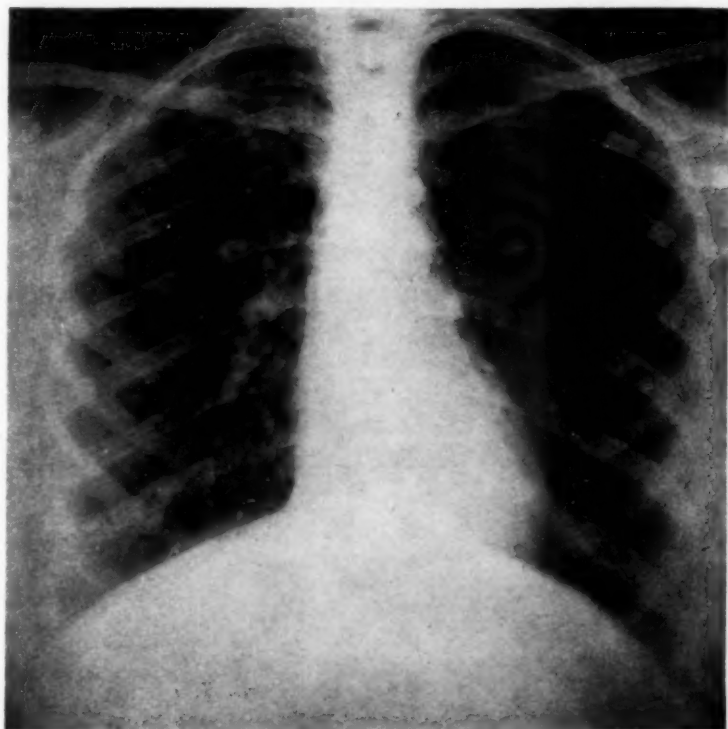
Chest roentgenogram of patient 150, M. Y. Findings for right lung in per cent of total. Oxygen intake: 58; tidal air: 49; vital capacity: 51.
